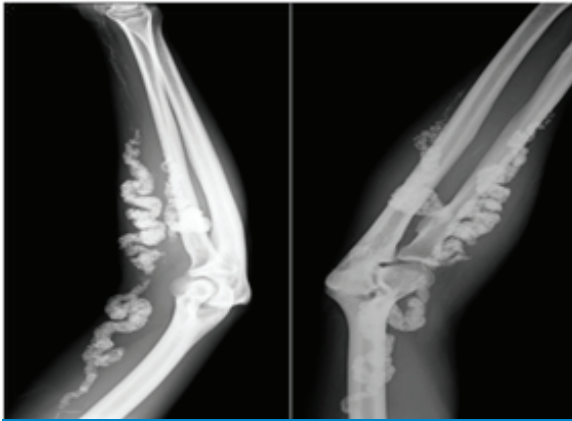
X-ray limbs showing periarterial calcification
